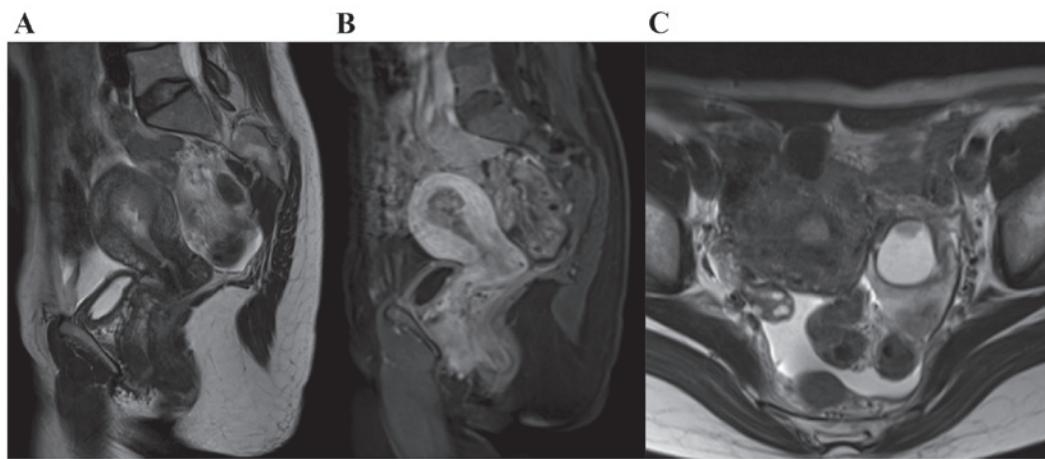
Pelvic magnetic resonance imaging: (A) T2-weighted sagittal, (B) T1-enhanced sagittal and (C) T2-weighted horizontal. (A and B) Endometrial tumor exhibiting invasive growth into the myometrium. (C) Left ovarian tumor with a solid component.
